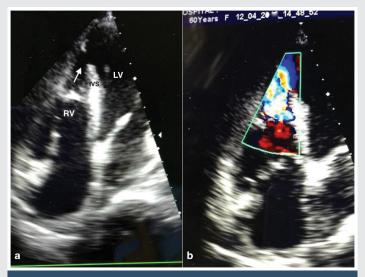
a) Transthoracic echocardiography in four-chamber view showing a defect in apical ventricular septum (arrow) b) Color Doppler showing left to right flow.
